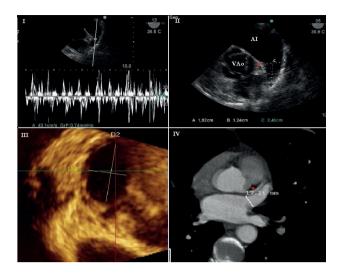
Top, left: Transesophageal Doppler examining LAA flow (velocity 42 cm/sec). Top, right: 2D echocardiographic image, which is very useful to measure the ostial diameter (dotted line A), as well as the LAA extension (dotted line B). Down, left: three-dimensional reconstruction of the LAA ostium. Down, right: angiotomography LAA image; notice the association between LAA and the circumflex artery.
